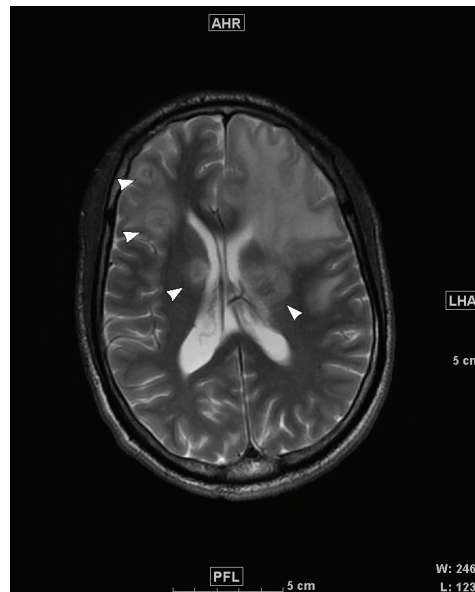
T2 FLAIR imaging at a slightly higher level reveals smaller lesions in the right hemisphere (arrowheads).
